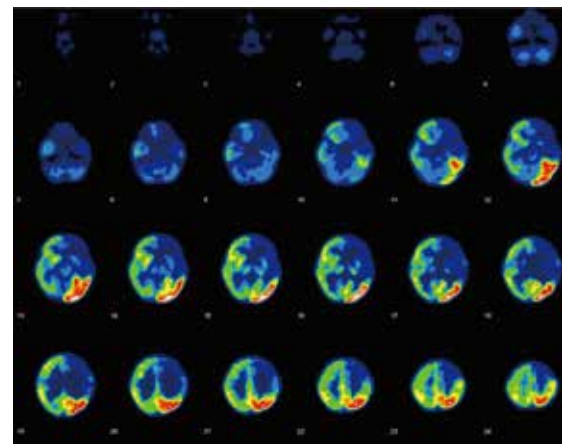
FDG PET images were obtained two days after SPECT, showing a large hypometabolic area at left frontal and left temporal lobes. Besides, an active inflammatory process at left occipital to posterior parietal lobe was suspected.
